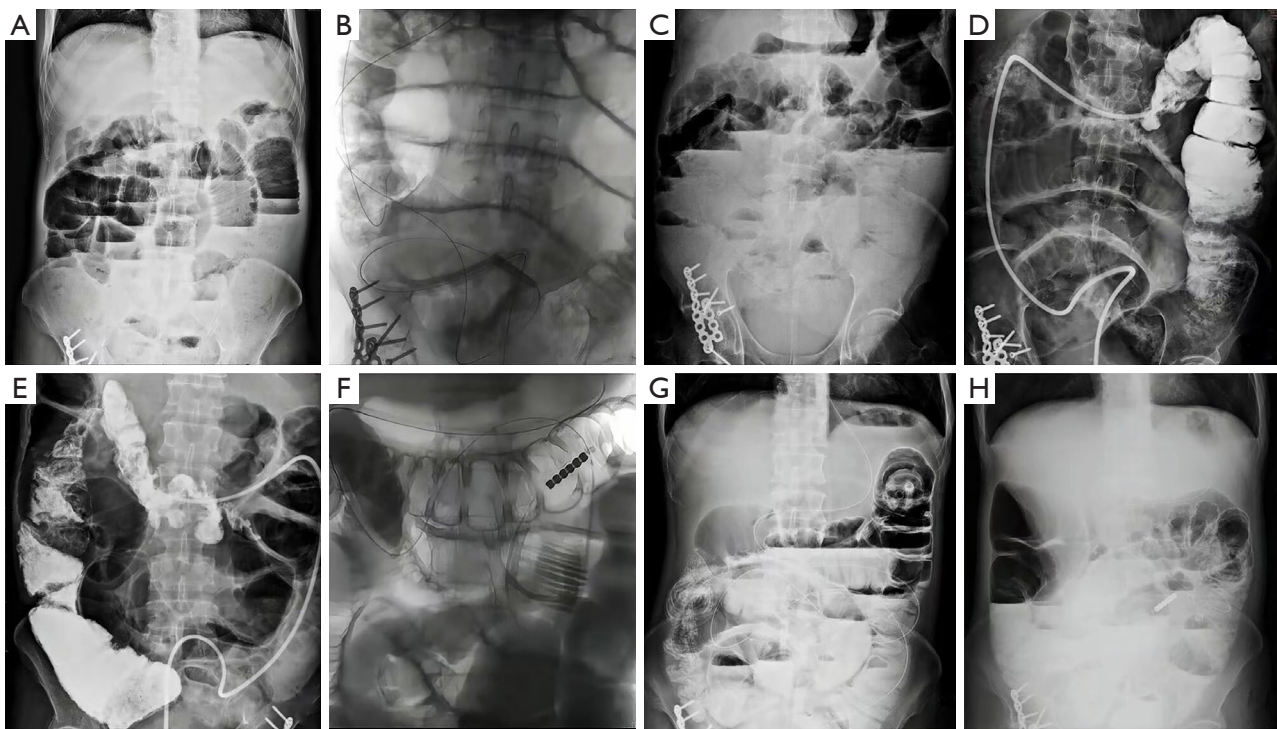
Treatment course for patient 9. (A) Multiple air-fluid level shadows arranged in steps on standing abdominal plain film 1 day before operation; (B) transanal intestinal obstruction catheter was placed; (C) re-examination of standing abdominal plain film 1 day after operation showed insignificant reduction of air-fluid level shadows; (D) poor effect by transintestinal obstruction catheter angiography; (E) multiple local stenosis in ascending colon and right transverse colon; (F) transnasal intestinal obstruction catheter insertion; (G) reduction of air-fluid level shadows on gastrointestinal radiography 2 days after combined catheterization; (H) re-examination of standing abdominal plain film 3 days after operation showed significant relief of intestinal obstruction.
